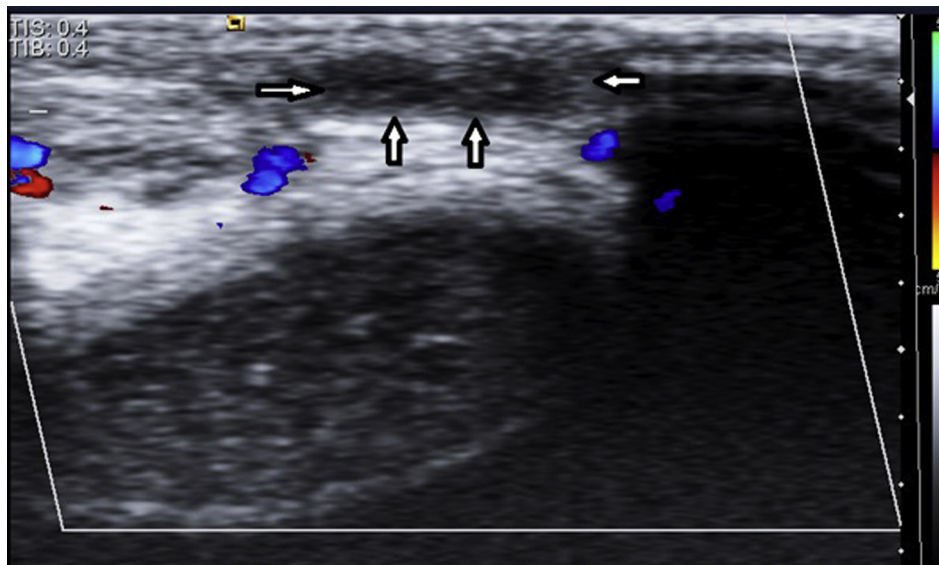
Color Doppler ultrasound showing thrombosis of the superficial dorsal vein of the penis (arrows). When there was current flow in the other veins of the penis, this was not monitored in the superficial dorsal vein.
